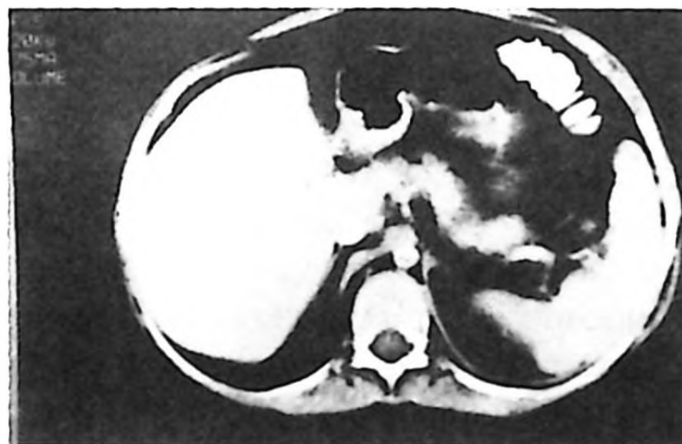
A CT scan of the abdomen after chemotherapy showing no metastatic lesions of liver (Case 7).
